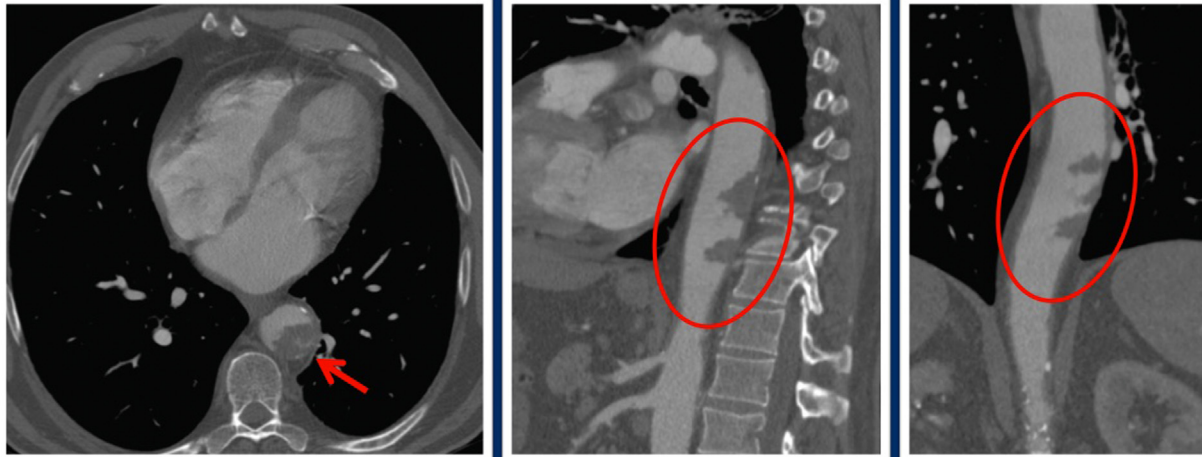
Computed tomography angiographic images showing, in the descending aorta, prominent, irregular, vegetating, dense soft tissue repletion defects (30-40 HU; marked in red), extending from L8 to L11 (62 mm long), and seated in the posterior and external wall of the aorta.
